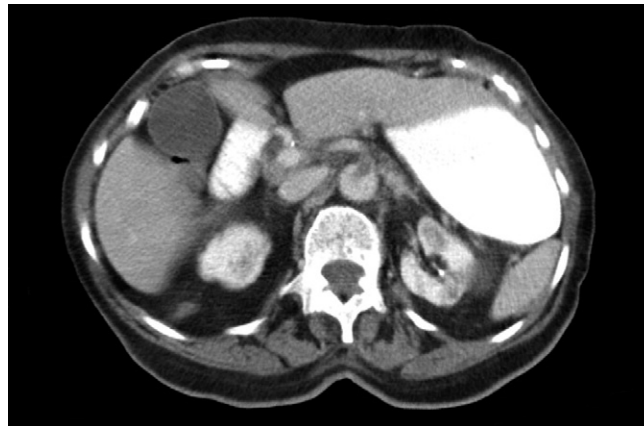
CT scan. Used with permission of Wilson Pyle, MD, Baystate Medical Center, Department of Emergency Medicine, Springfield, MA.
